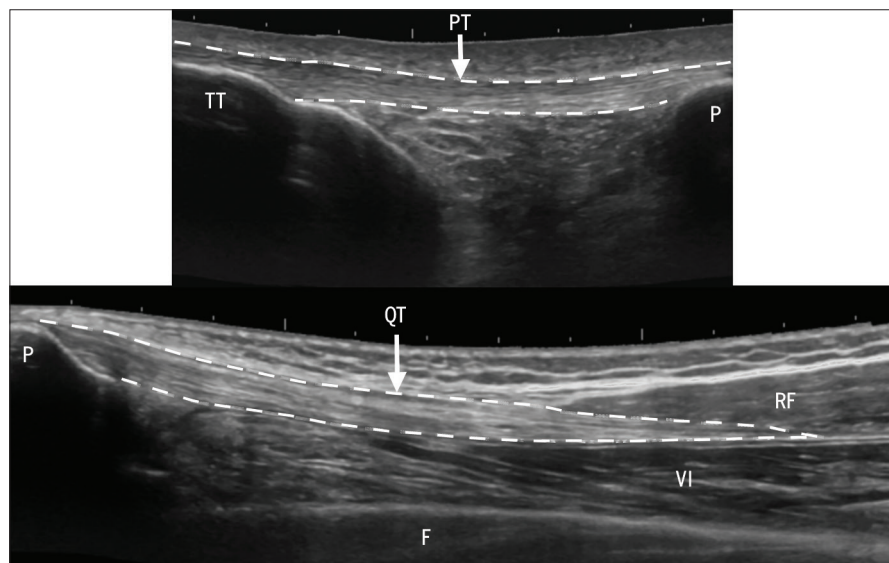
Longitudinal ultrasound images of uninjured patellar and quadriceps tendons. Abbreviations: F, femur; P, patella; PT, patellar tendon; QT, quadriceps tendon; RF, rectus femoris; TT, tibial tuberosity; VI, vastus intermedius.
